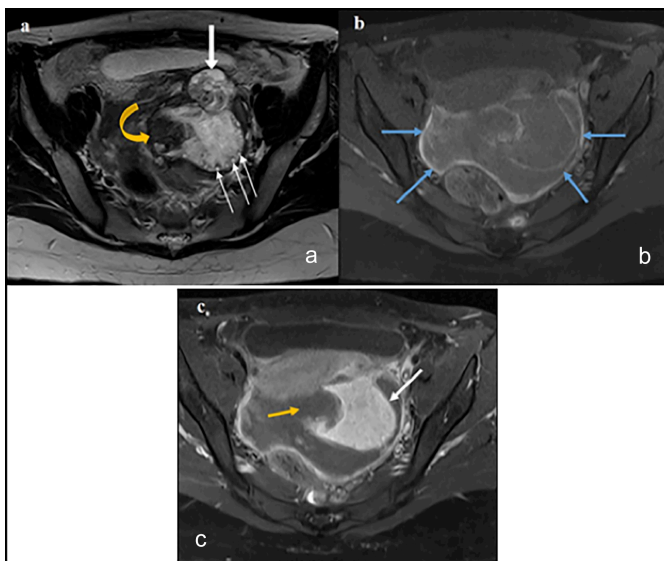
(a) Axial T2 weighted MRI image shows enlarged left ovary with tiny peripherally displaced hyperintense follicles (thin white arrows) and a T2 hypointense area representing a haemorrhagic cyst (curved yellow arrow). The twisted pedicle is seen anterior to the ovary (thick white arrow), (b) Axial T1 weighted fat saturated MRI image shows pelvic collection with hyperintense rim (blue arrows) indicating blood products/haemorrhage, (c) Axial post-contrast T1 weighted fat saturated MRI image shows enhancing left ovary (white arrow) and a defect in its right wall due to ruptured haemorrhagic cyst (yellow arrow).
